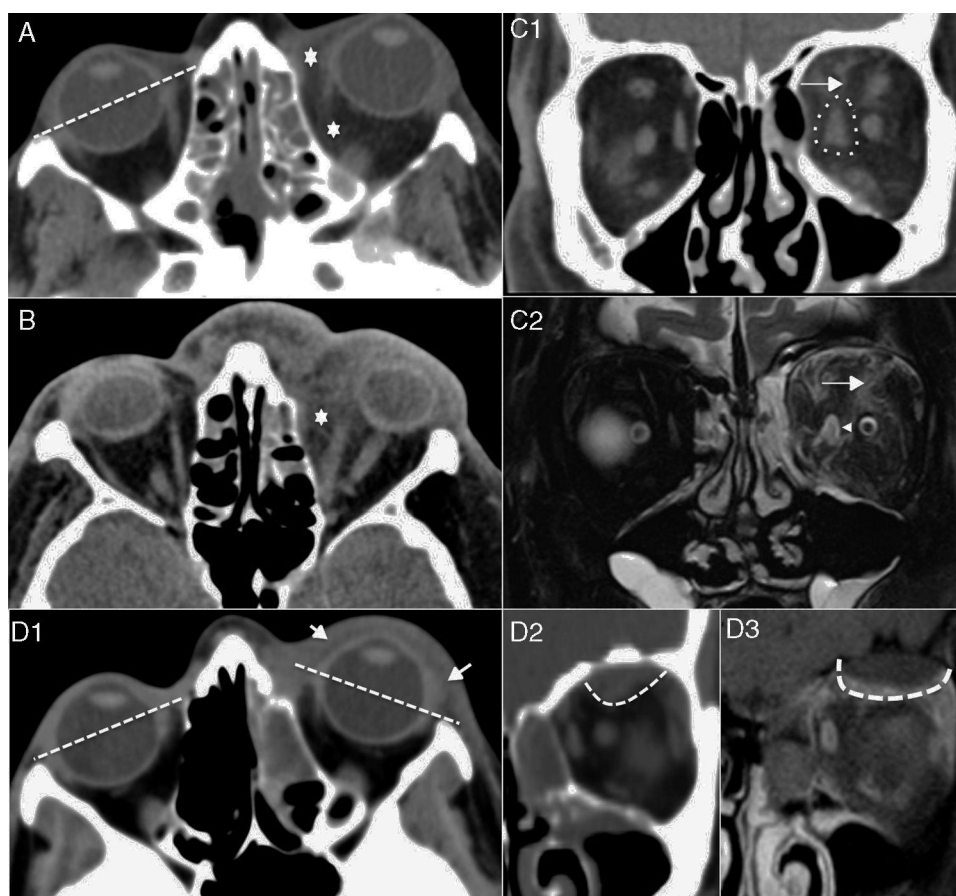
Retroseptal orbital cellulitis. (A and B) Axial computed tomography (CT). Two phases of a progressive condition. There is an increase of preseptal and retroseptal fat density (asterisk) associated with mild proptosis. The separation of the septal and retroseptal regions has been indicated in the contralateral orbit (dotted line). (C1) Coronal CT. There is a greater retroseptal affection than in A and B. Small liquid linear collections (arrow) and increase in the caliber of medial rectus muscle (dotted ellipsis). (C2) T2-weighted MRI coronal section with fat saturation at the same level as C1. The collections (arrow) and the myositis (arrowhead) can be seen more clearly. (D1) Axial CT of another patient who presented with clinical manifestations of cellulitis associated with proptosis and eye movement limitation. The axial CT only showed an increase of fat density at the preseptal level (arrows). (D2) Coronal CT. The coronal reconstruction allowed us to objectify the presence of a subperiosteal abscess on the orbital roof (dotted line). (D3) T1-weighted MRI coronal section with fat saturation and gadolinium. The intraorbital affection was observed more clearly on the MRI than on the CT.
